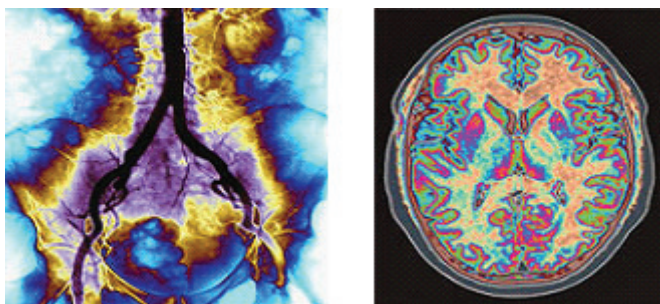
Digitally enhanced MRI images of the brain.
